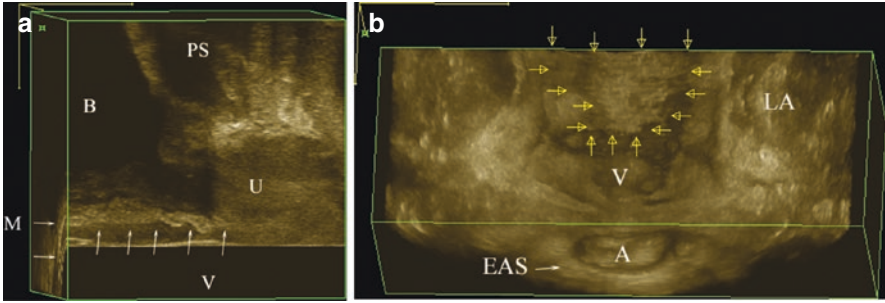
(a) 3D endovaginal ultrasound image (anterior compartment) in sagittal plane showing the anterior vaginal wall mesh (M). Bladder (B), urethra (U), vagina (V), pubic symphysis (PS). (b) 3D coronal tilted view of the posterior compartment obtained using an endovaginal probe. *Arrows* point to the edges of the posterior mesh. External anal sphincter (EAS), vagina (V), levator ani (LA), anus (A). (© Shobeiri)
